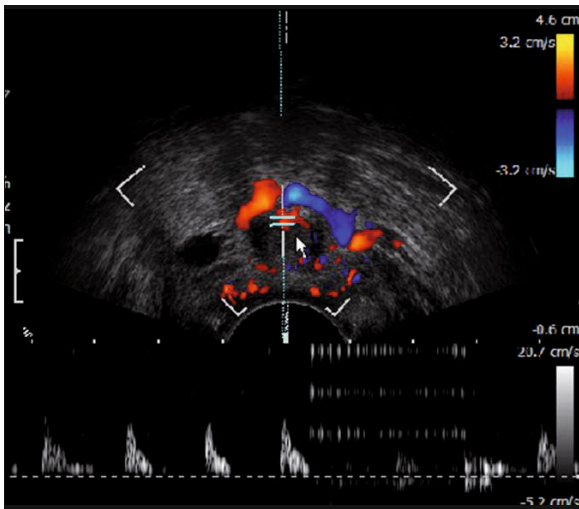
Vascularity of the urethra assessed in the axial plane by color Doppler. Scan obtained by 8848 transducer (B-K Medical)
